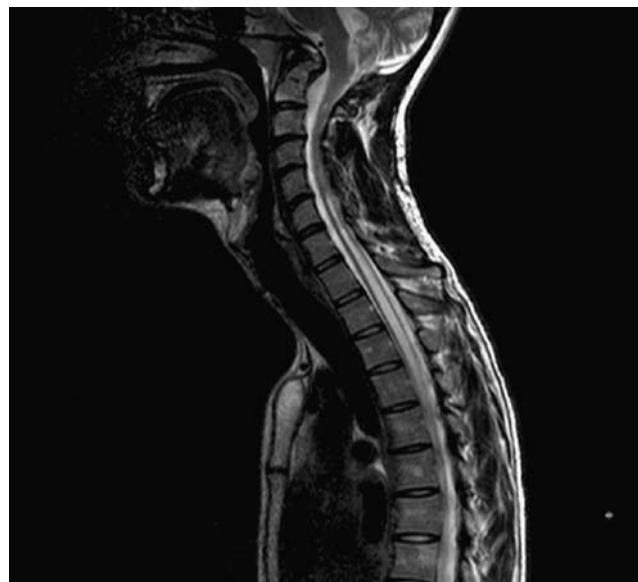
Post-operative T2-weighted magnetic resonance imaging showing decrease in the size of the syrinx cavity
